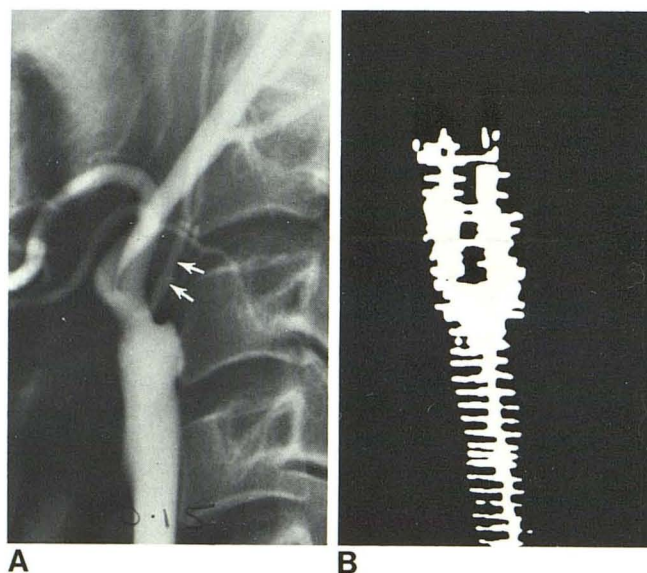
Incorrect recognition of carotid bifurcation.* A, Ascending cervical collateral (arrows) was mistaken for internal carotid, resulting in false-negative diagnosis of occlusion. Weak (low amplitude) signals in vessel were attributed to short "thick" neck of patient, which was difficult to examine. B, Doppler image.
